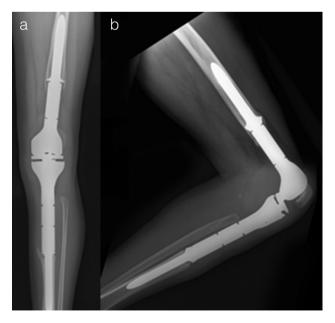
Anteroposterior (a) and lateral (b) radiograph of combined distal femur and proximal tibia reconstruction.
